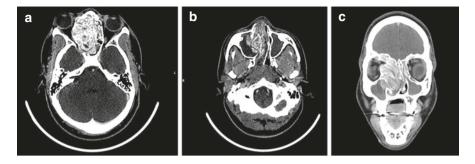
Para nasal sinus computed tomography scan of a patient with progressive headaches and right eye proptosis. An extremely heterogeneous opacification with multifocal high-density areas is seen within the frontal, ethmoid and sphenoid sinuses (\mathbf{a} , \mathbf{b}). Multiple sinuses demonstrated expansion causing distortion of the nasal cavity and optic nerve displacement (\mathbf{c})
